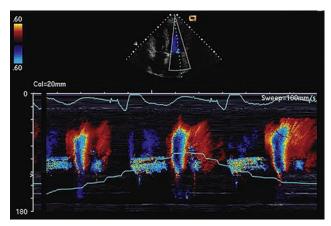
CP: apical four-chamber view with color M-mode through the mitral valve in a patient with CP. The slope of the propagation velocity of early diastolic flow is obtained by measuring the slope of the first aliasing velocity from the mitral coaptation 4 cm into the LV cavity. Typically, the Nyquist limit should be baseline shifted to about 30 to 40 cm/sec to demonstrate aliasing of propagation velocity (not done in this example). Note the rapid slope (100 cm/sec) in this patient.
